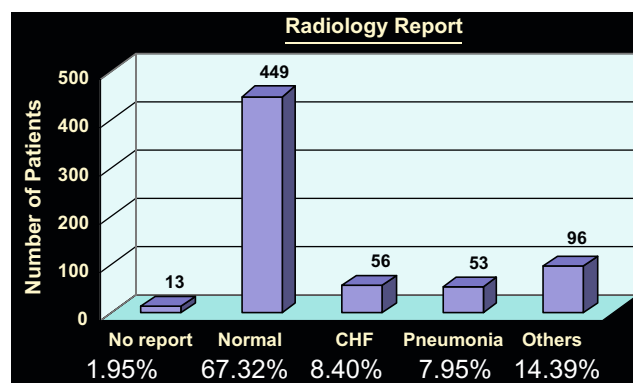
Distribution of radiologist interpretations of 667 chest radiographs. CHF congestive heart failure
